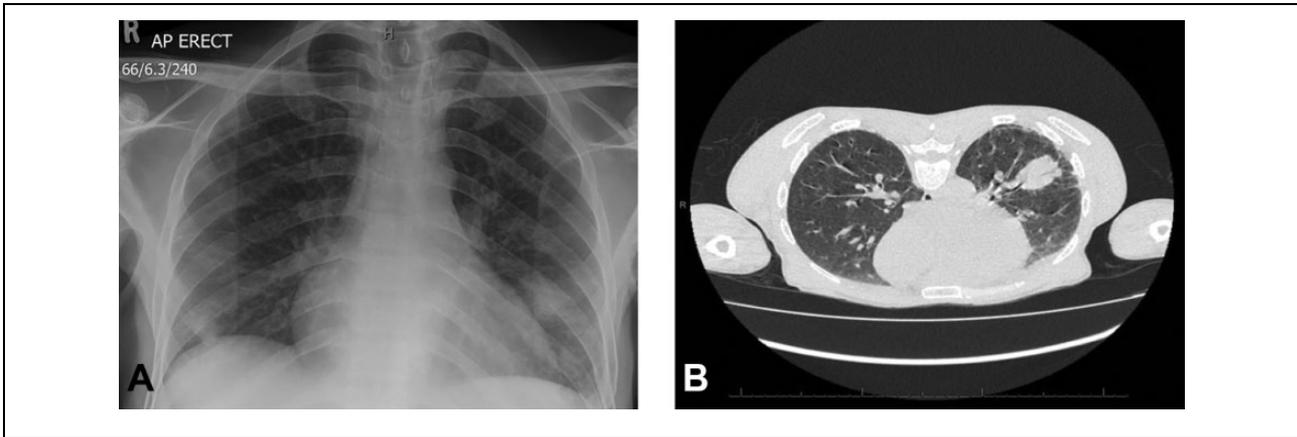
Pretreatment imaging. (A) Chest radiograph showing a mass in the left lower lobe and smaller nodules in both lower lobes. (B) Computed tomography scan showing an irregular mass in the left lower lobe measuring $37 \times 28 \times 26$ mm. There are also multiple subpleural nodules.
